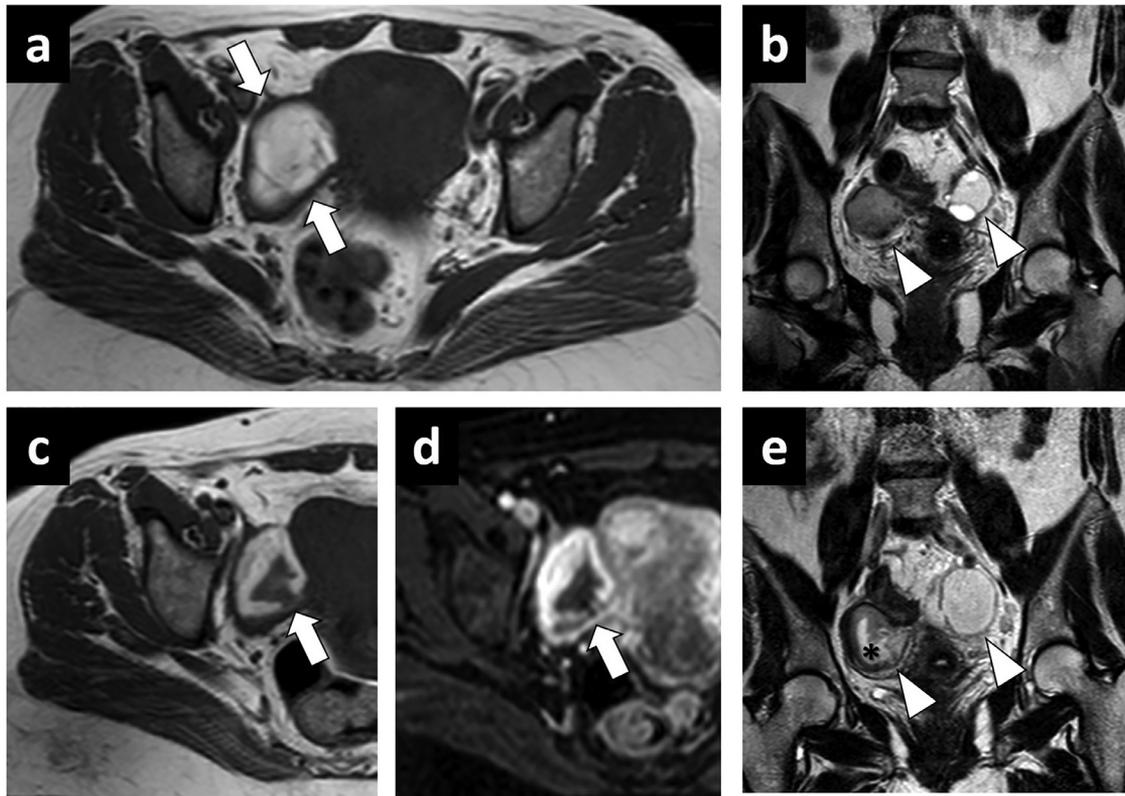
Early signal changes in the right-sided endometrioma. (A and B) Axial plane T1W (A) and coronal plane T2W (B) baseline pelvic MR images 6 months before the patient’s clinical presentation show initial T1 signal characteristics of the right-sided endometrioma (arrows, A) and T2 signal characteristics of bilateral endometriomas (arrowheads, B). (C–E) Axial plane T1W (C), T1W fat-suppressed postcontrast (D), and coronal plane T2W (E) MR images at the time of clinical presentation demonstrate focal reversal of T1 signal hyperintensity in the medial part of the right-sided endometrioma with no apparent enhancement (arrows, C and D), and corresponding T2 hyperintensity in this area (black asterisk, E). Note was also made of the enlargement of bilateral adnexal lesions in the 6-month interim (arrowheads, E).
